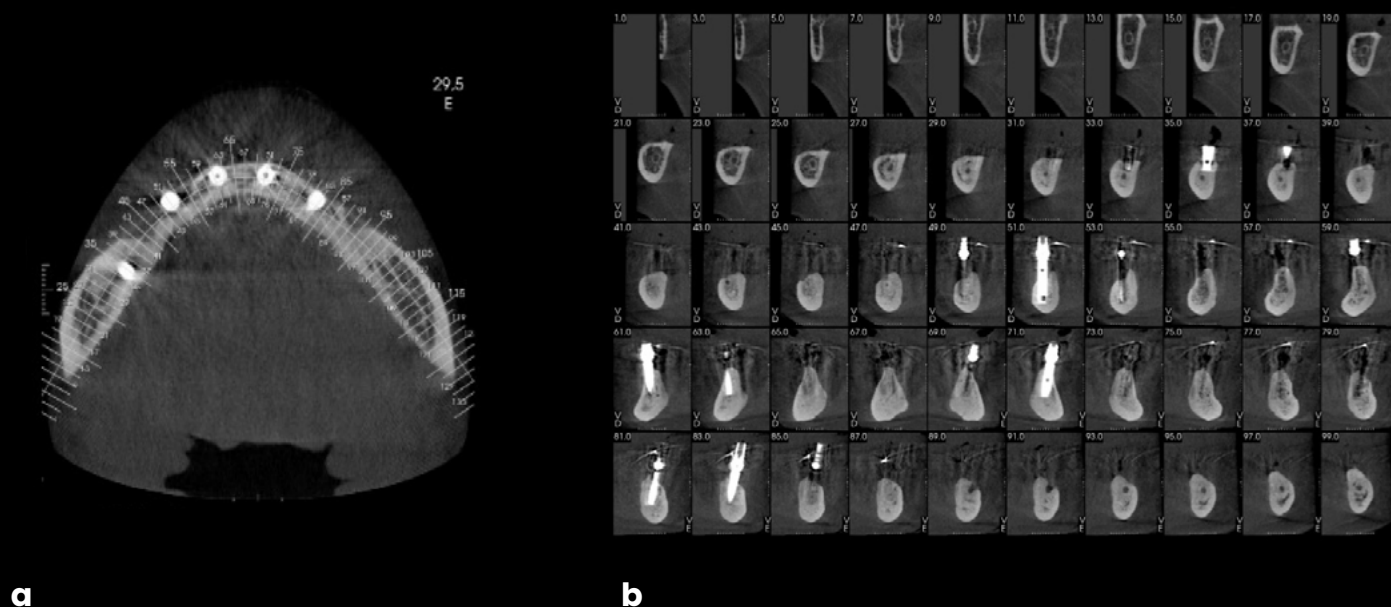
Postoperative follow-up by computed tomography (CT), November 2020 (a: coronal section) (b: sagittal section).
